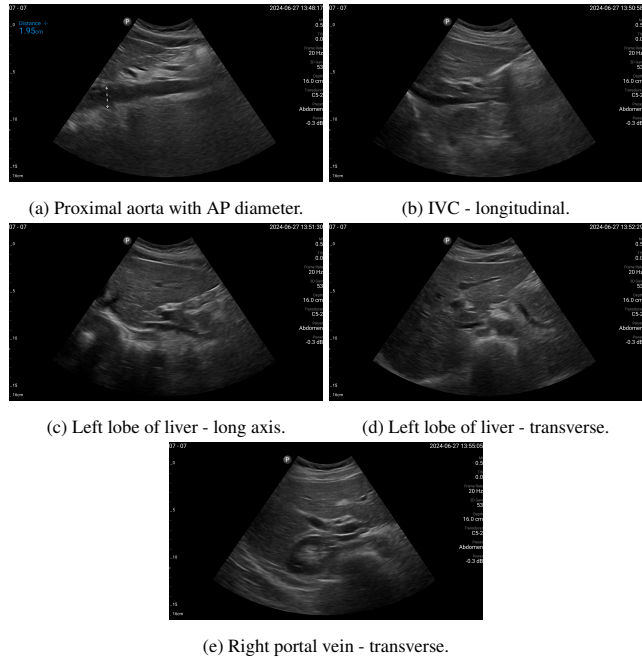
Example of the target US images acquired by the sonographers using the human teleoperation system.
